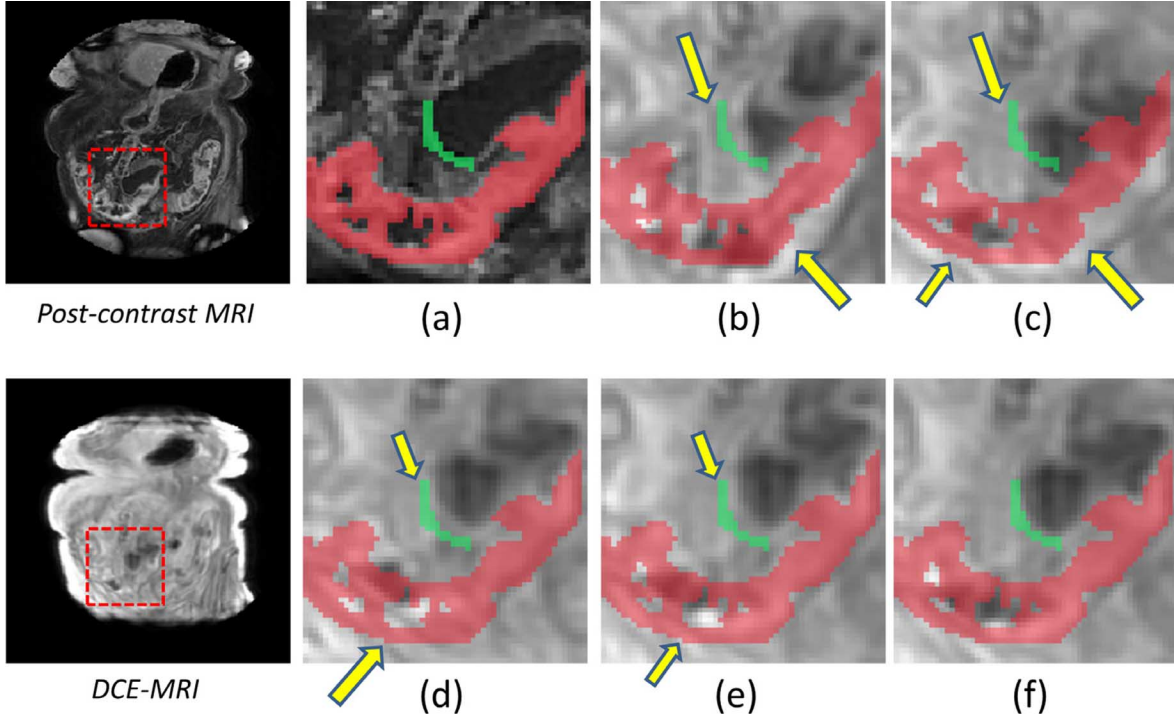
An abdominal MR image showing a large bowel deformation in a post-contrast MR image (fixed image); DCE-MR image (moving image); (a) ROI in a sub-region of the post-contrast MR image (the red region is affected by Crohn's disease, the green region is healthy bowel wall); (b-f) same ROIs copied to the registration based on NMI (b), MIND_I (c), MIND_MP (d), MIND_PC (e), and ALOST (f). The yellow arrows point to a misregistration area in which the size of the arrow represents the amount of misregistration.
